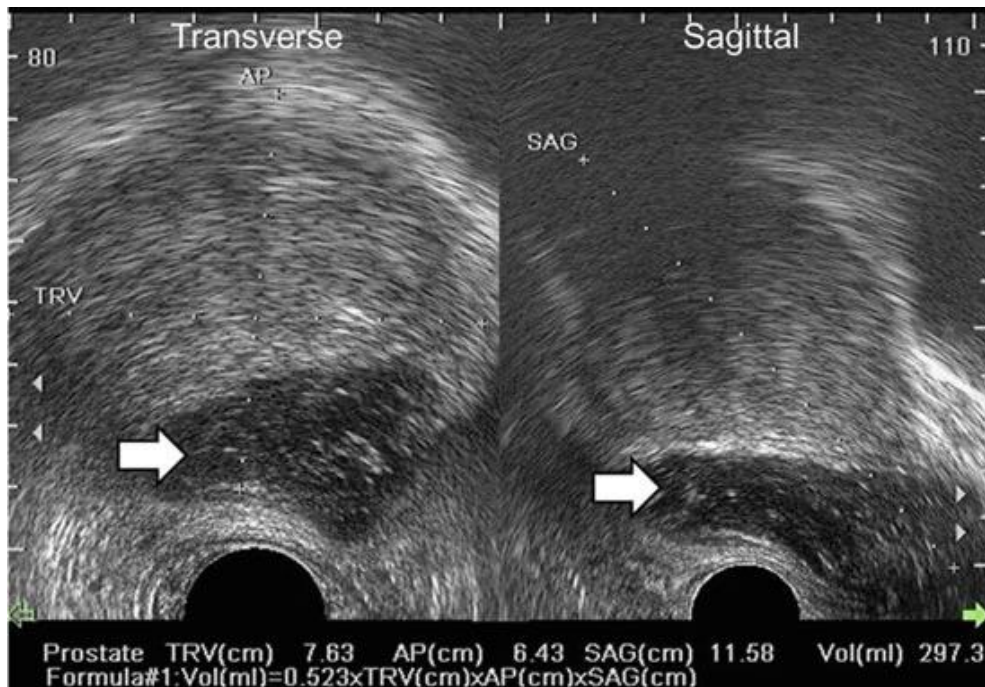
Transrectal sagittal sonogram of the prostate demonstrating abscess. Prostate abscesses (arrows) appear as hypoechoic lesions with hyperechoic fossa consistent with gas bubbles on axial and sagittal views (1).
